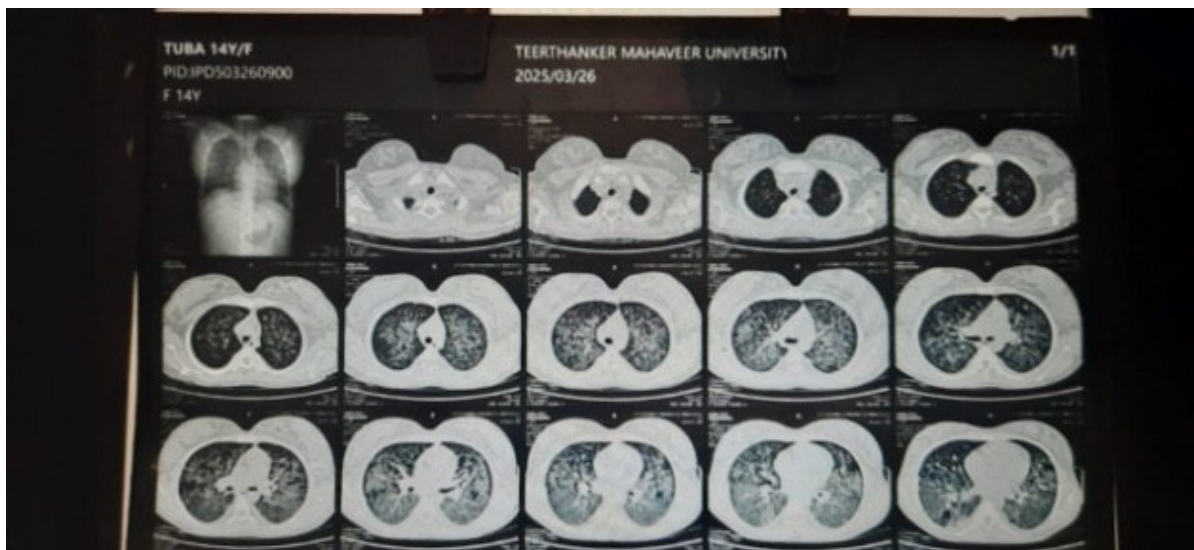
CT chest showing symmetric infiltrations in both lung fields suggestive features of pulmonary edema along with minimal bilateral pleural effusion
